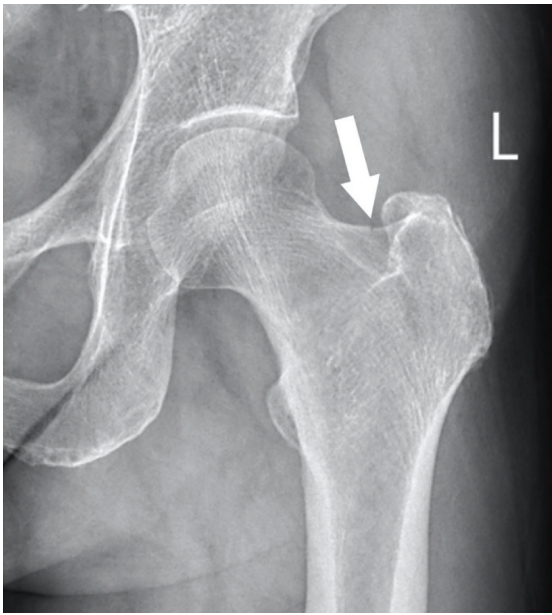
Plain radiograph showing cortical disruption at the lateral border of the neck of the left femur.
